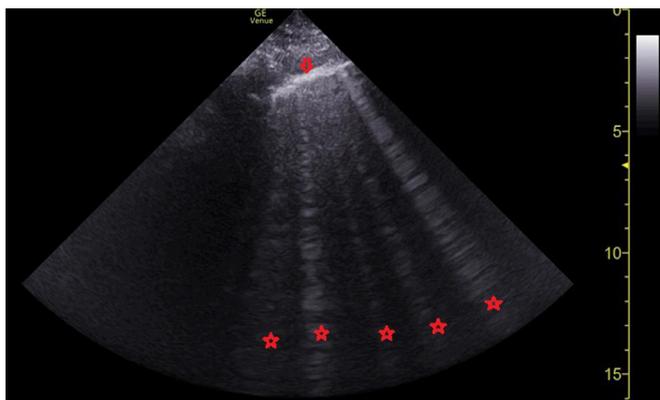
Right lung ultrasound with B lines (stars) and thick pleura (arrow) consistent with a B/C profile, and therefore, a pneumonia.
